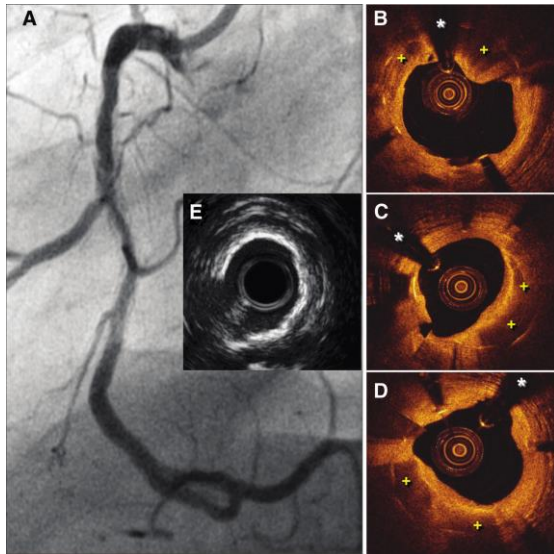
A, Angiography (lateral projection) showing diffuse in-stent restenosis (ISR). B through D, Optical coherence tomography images revealing calcified intrastent tissue (plus sign) with variable morphology and degree of lumen obstruction (asterisk denotes wire artifact). E, Intravascular ultrasound imaging disclosing calcified ISR shadowing the underlying stent struts.
